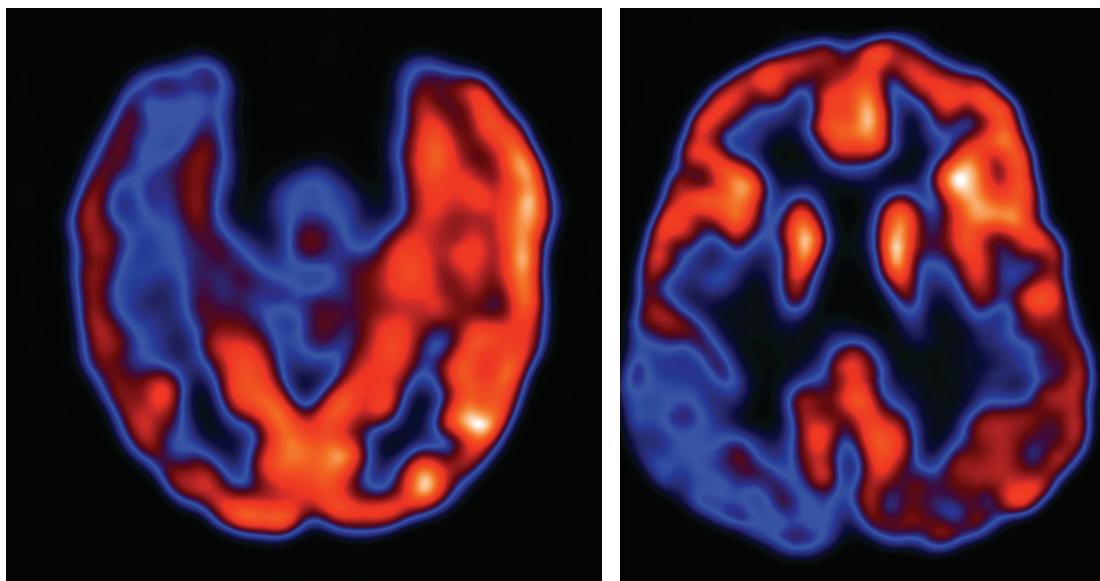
Interictal FDG-PET of parietal lobe epilepsy showing extensive area of hypometabolism.
